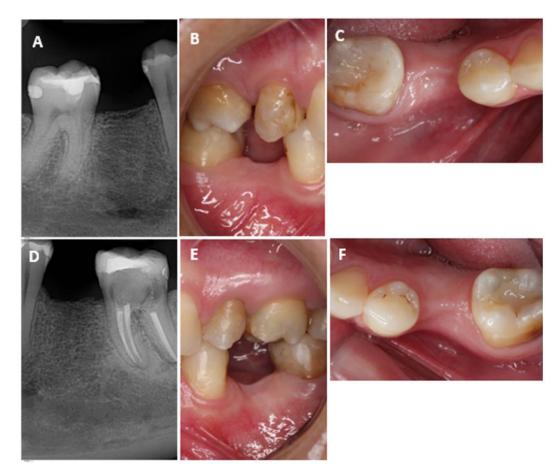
Patient's initial aspects. A) Periapical x-ray, B) lateral and C) occlusal view showing the absence of teeth 35. D) Periapical x-ray, E) lateral and F) occlusal view showing the absence of teeth 45.
